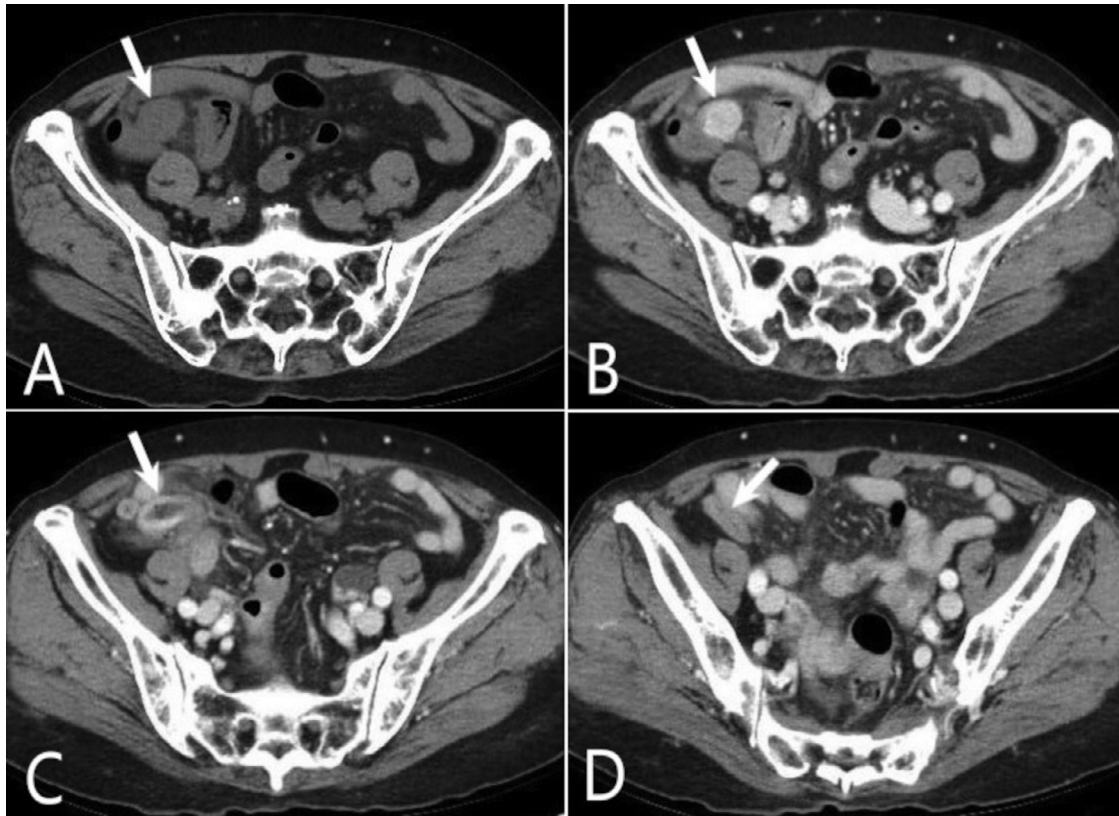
Axial computed tomography scans. (A, B) A well-defined ovoid homogeneously enhancing mass measuring 1.3 cm is seen at the cecal tip. (C, D) Distal appendix is dilated, with wall thickening, and surrounding fat infiltration.
